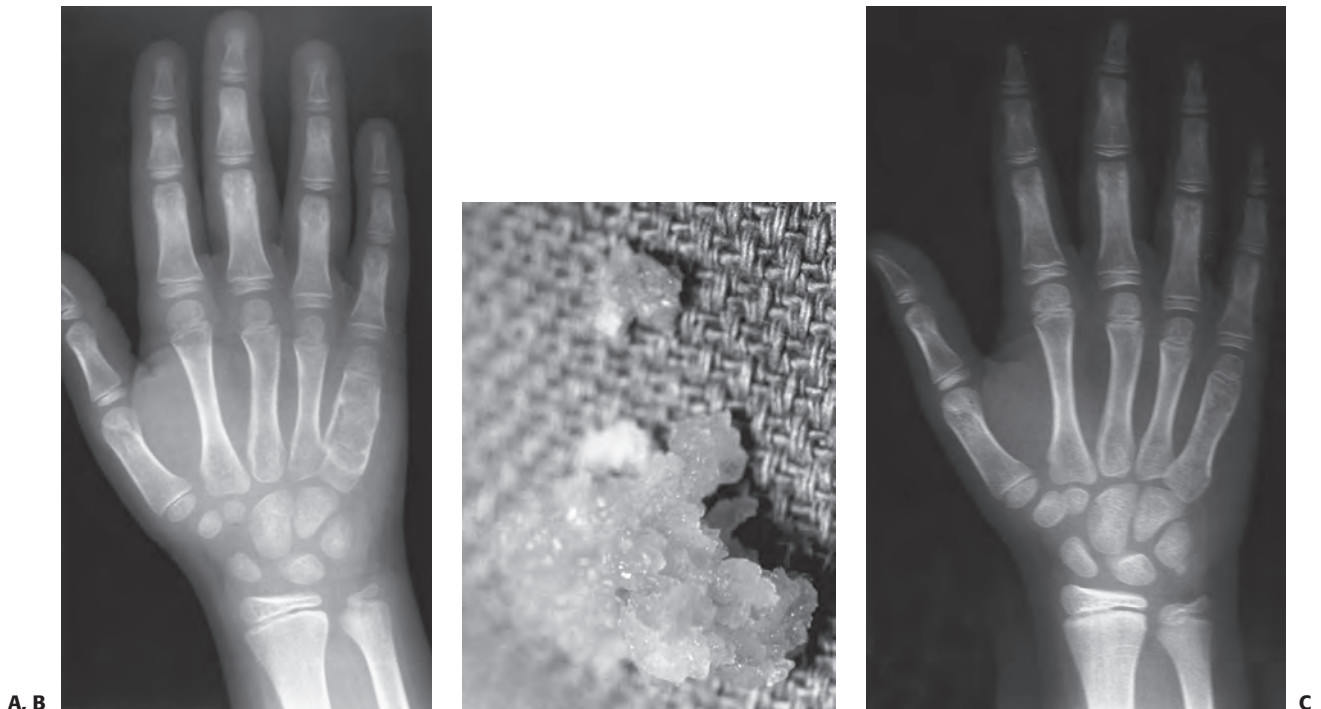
An 8-year-old boy presented with pain and swelling of the ulnar border of his right hand. A: Radiographic studies showed an expansile, lucent lesion of the diaphysis of the patient's right fifth metacarpal with microfractures. The patient had an open incisional biopsy with frozen section, which was consistent with enchondroma with subsequent curettage and bone grafting. B: Gross appearance of material removed at the time of surgery, which is consistent with enchondroma. C: At 6-month follow-up, the fracture is well healed, and there is no sign of recurrent tumor.
